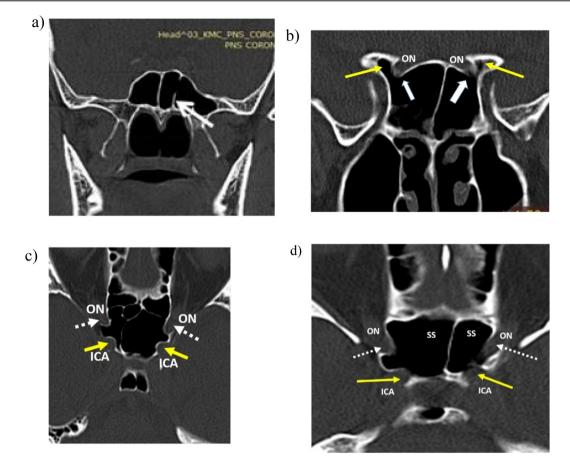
Anatomical variation in the sphenoidal sinuses identified in CT scan images. a) Coronal CT image of the sphenoidal sinus, showing left accessory sinus septa (white solid arrow). b) Coronal CT section showing bilateral anterior clinoid process pneumatization (yellow arrows) and bilateral protrusion of the optic nerve (ON) (white arrow) into the sphenoidal sinuses. Bilateral bone covering of the optic canal is absent. c) Axial CT section showing bilateral protrusion of the optic nerve (White dotted arrows) into the sphenoidal sinuses. Bilateral bone covers the optic canal and bilateral protrusion of the optic nerve (white dotted arrows) into the sphenoidal sinuses. Bilateral bone covers the optic canal and ICA. d) Axial CT section image, showing bilateral protrusion of the optic nerve with dehiscence of the optic canal covering (white dotted arrows) into the sphenoidal sinuses (SS). Bilateral dehiscence of the osseous covering of the ICA (yellow solid arrows) is present. *A Siemens AG Somatom spirit scanner was used to assess PNS anatomical variation*.
